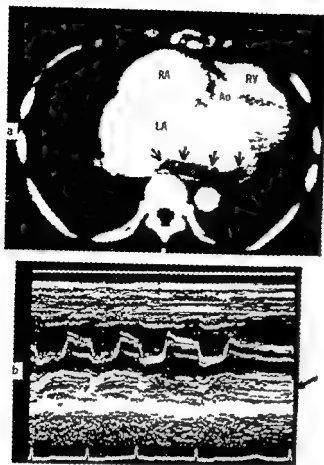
A patient with mitral stenosis-regurgitation, atrial fibrillation and two histories of cerebral thromboses (Case No 3) A computed tomogram at the level of the left atrium a thrombus (75 cm \times 17 cm \times 3 cm) is indicated by arrows RA = right atrium RV = right ventricle Ao = aorta LA = left atrium B echocardiographic findings in the same patient (the thrombus is indicated by an arrow)
